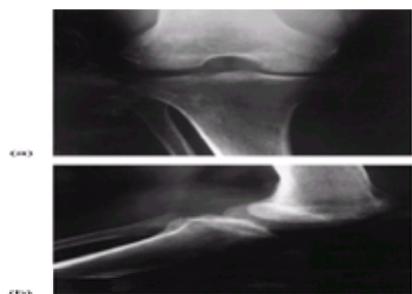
(a) and (b). Radiographs of the left knee demonstrating only patchy osteopenia of the distal femur and proximal tibia from a patient with joint infection caused by *S. schencki*. Bone scintigraphy of the same patient is shown in [Fig. 1](#) (by courtesy of Jesse Hofflin MD).
